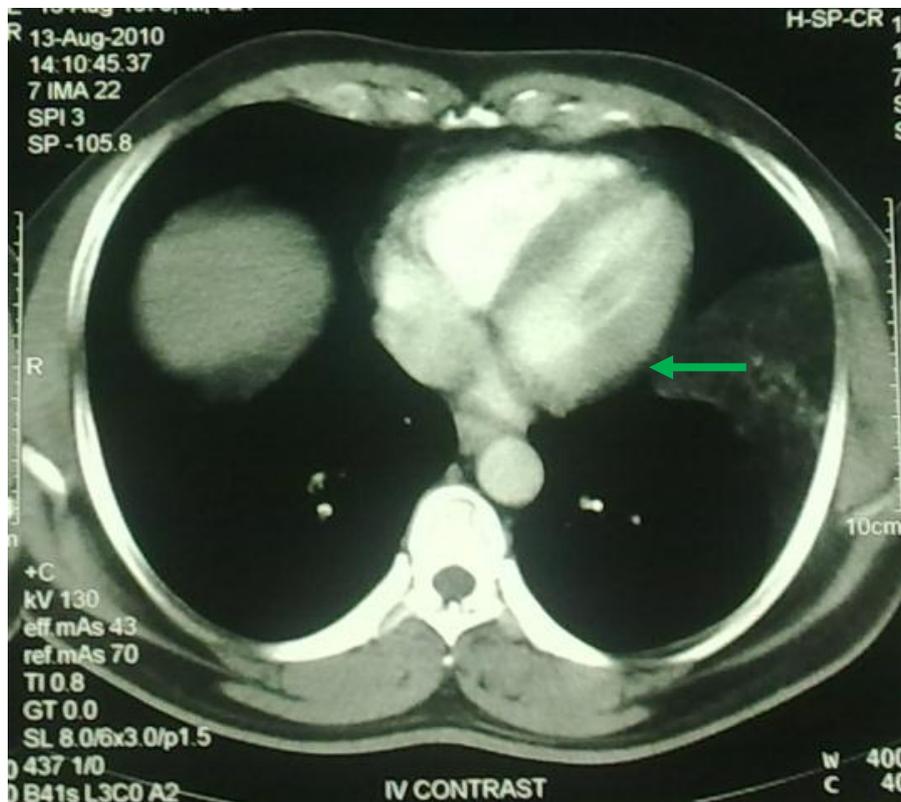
Computed tomography Chest Mediastina window showing soft tissue density of the Diaphragm (Green arrow)
